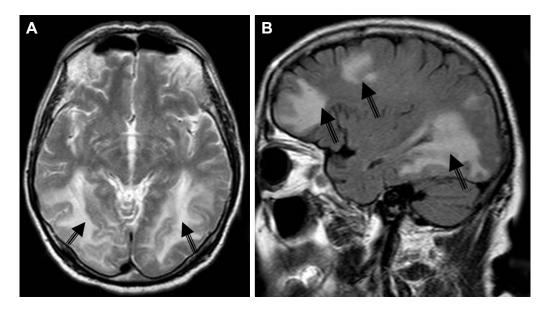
(A) Axial T2 magnetic resonance image at presentation shows extended areas of high signal in the white matter (vasogenic edema) symmetrically in the bilateral occipital lobes (indicated by arrows). (B) Sagittal fluid-attenuated inversion recovery (FLAIR) magnetic resonance image at presentation shows extended areas of high signal in the white matter (vasogenic edema) in left frontal and occipital lobe (indicated by arrows).
